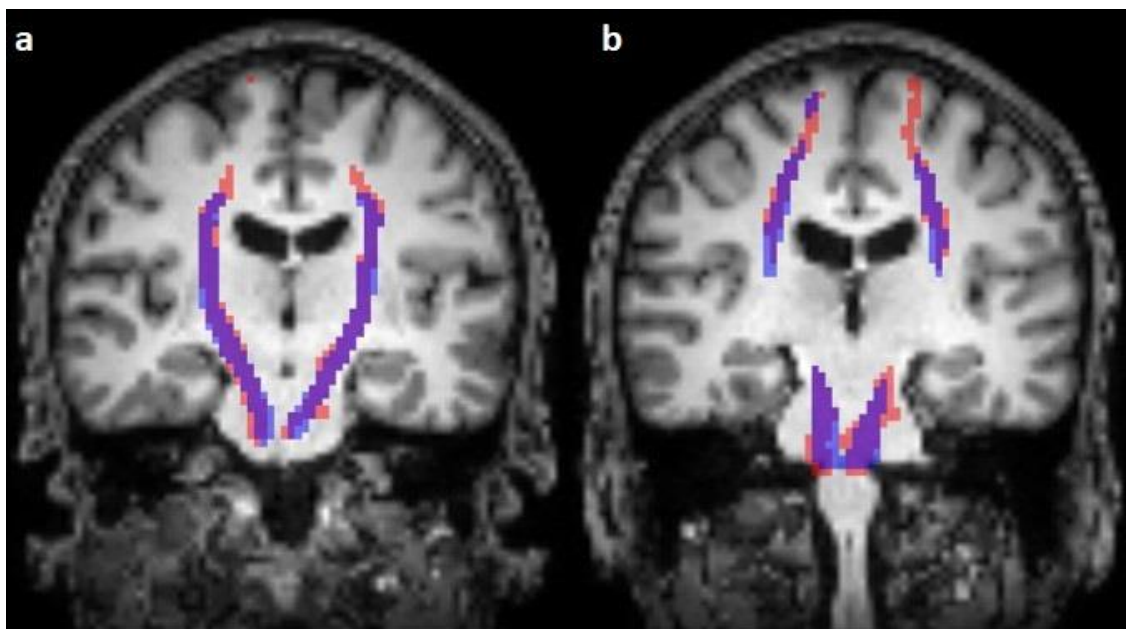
Comparison of the predicted (blue) and reconstructed (red) course of the corticospinal tract on coronal T1-weighted images (a,b).
